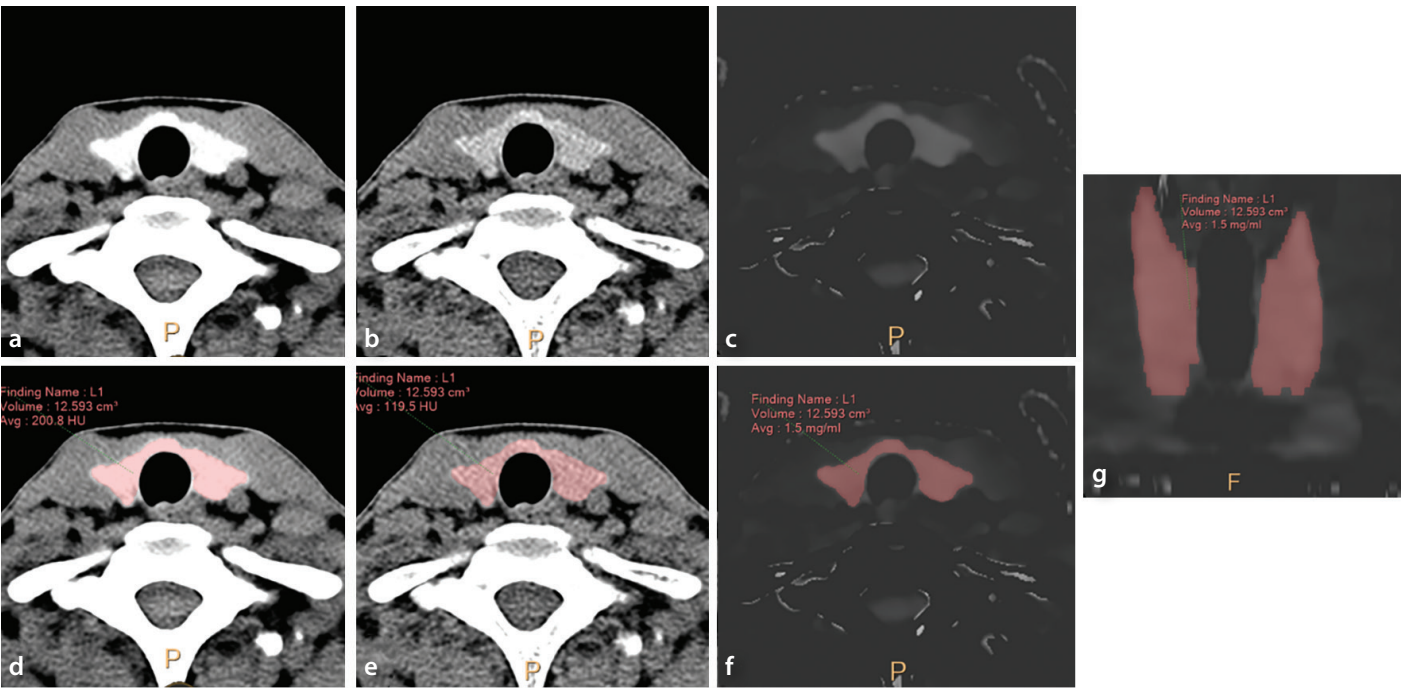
Example of thyroid parenchymal iodine concentration (IC) measurement. Initially, the volumetric region of interest encompassing the entire thyroid glands was drawn on the axial 40-keV virtual monoenergetic images (a, d) using the semi-automated region-growing method. Then, both mean CT attenuation value and IC were obtained from the corresponding iodine density map (c, f, g) and conventional CT images (b, e). Total thyroid volume was also recorded. keV, kiloelectronvolt; CT, computed tomography.
